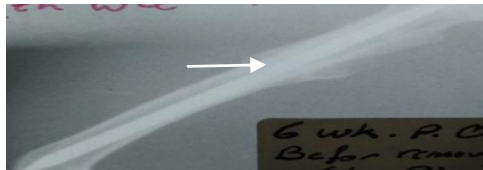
Radiographic image end of sixth week p. o. radiological union white arrow represents bony bridge formation; with hard callus formation
